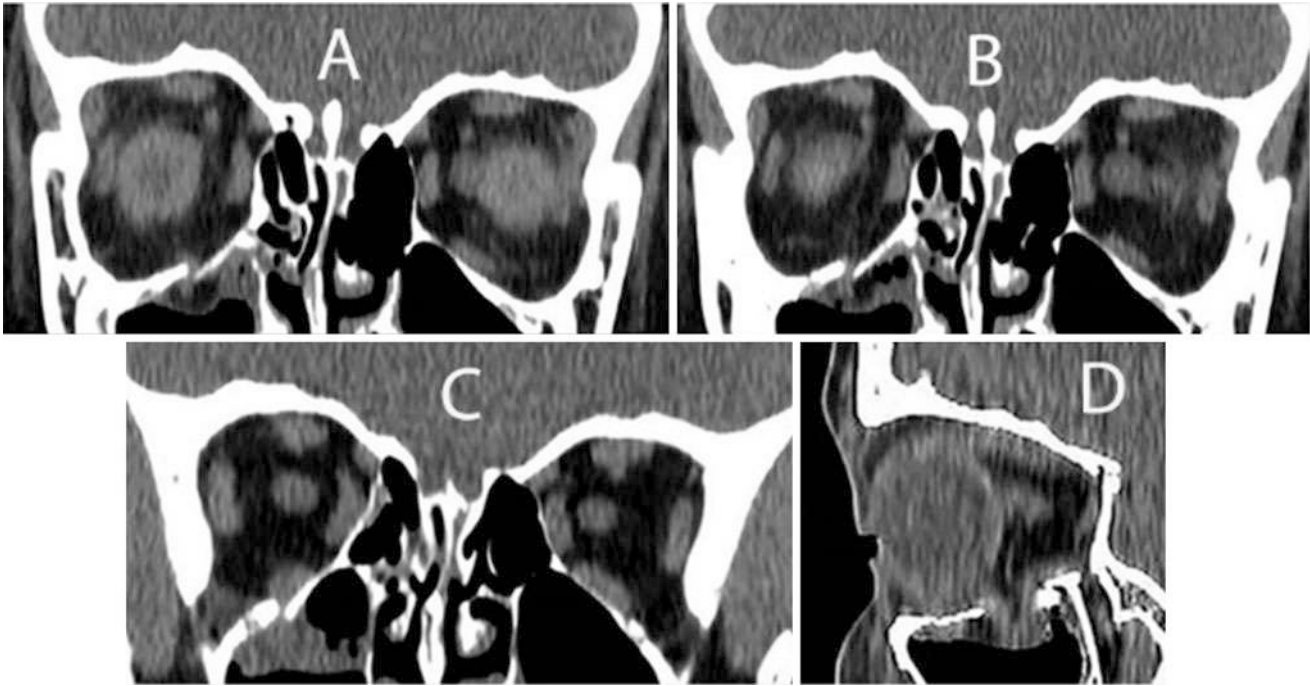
CT soft tissue window: Trapdoor fracture of the right orbit with inferior rectus herniation and entrapment. Serial anterior to posterior coronal sections (a-c): Note the IR is not visible intraorbitally in figures A and B, but visible posteriorly (d). (Courtesy: Dr Guy Ben Simon)
